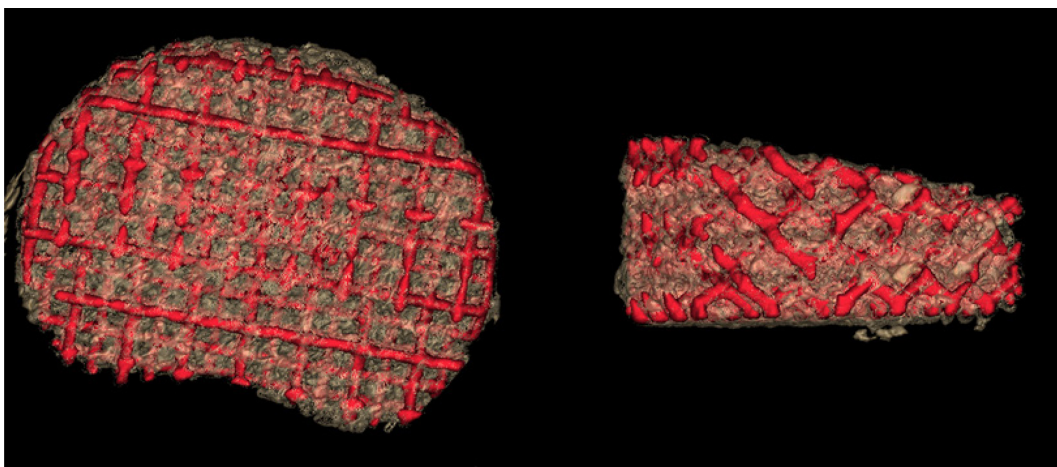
CBCT images of titanium-bone sample. Titanium mesh is colored red.
